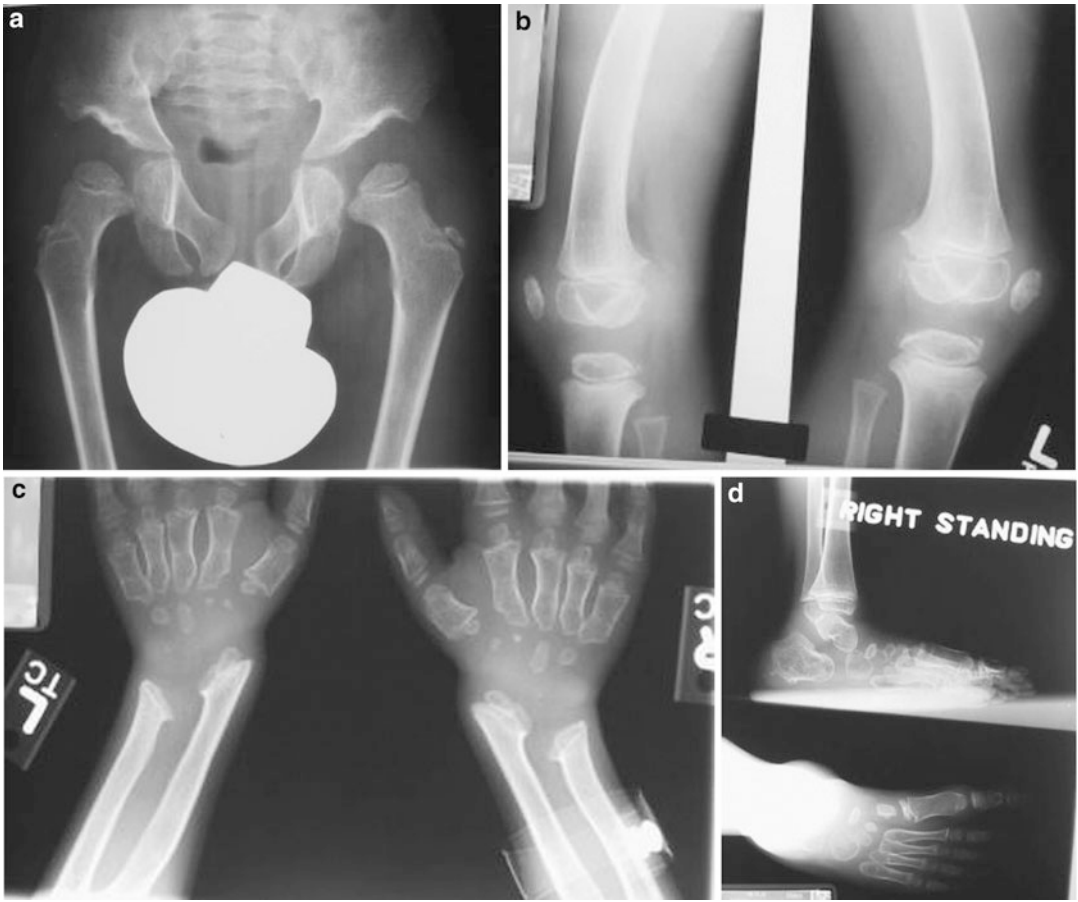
(a–d) Radiographic studies showing dysostosis multiplex with proximal conical metacarpals and angling of the ulna toward the radius with dysplastic ulnar and radial growth plates
